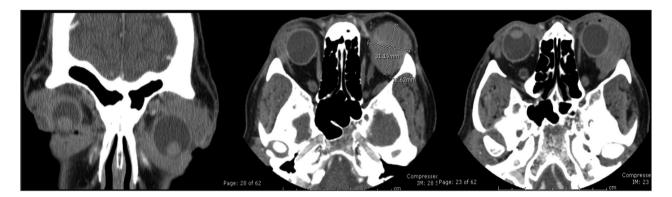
Coronal and axial CT images of intraconal and extraconal orbital mass. Postcontrast CT orbital images. Postcontrast CT of the orbit demonstrates intraconal and extraconal mass of the left orbit measuring 31.19 mm x 32.62 mm involving the lacrimal gland and molding to all surrounding structures without bony erosion.
